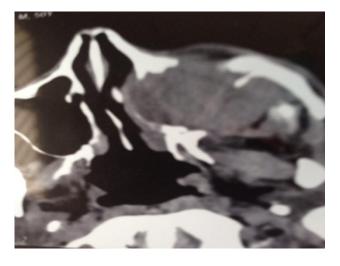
CT scan axial view showing maxillary sinus pathology with orbital involvement.
